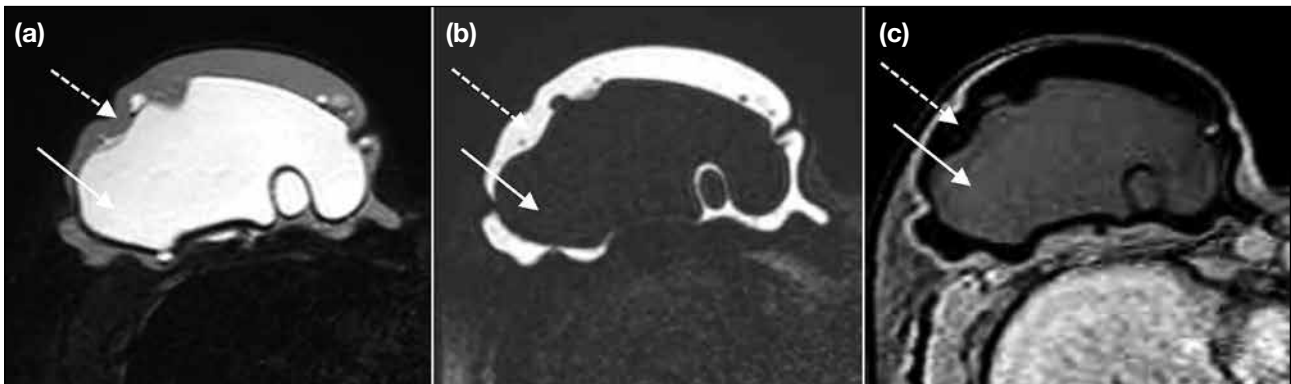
Inverse double-lumen implant, with saline gel in the inner lumen (solid arrows) and silicone solution (dashed arrows) in the outer lumen. (a) Short-tau inversion recovery magnetic resonance imaging showing the saline hyperintense inner lumen (solid arrow) and (b) silicone-only sequence showing the hyperintense silicone gel (dashed arrow) in the outer lumen. (c) In silicone-suppressed image, there is an exact reversal of the signal pattern, showing the saline inner lumen (solid arrow) with intermediate signal and the hypointense silicone gel (dashed arrow) in the outer lumen.
